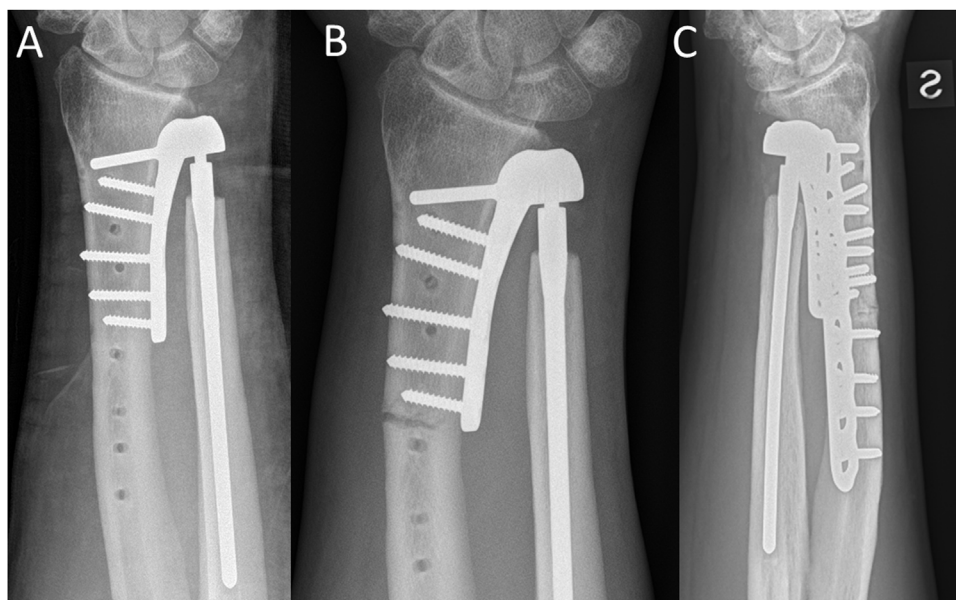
Postoperative PA wrist X-ray in patient 1 (A). Periprosthetic fracture of the radius after plate removal and endoprosthesis implantation (B). Osteosynthesis of the periprosthetic fracture (C).
